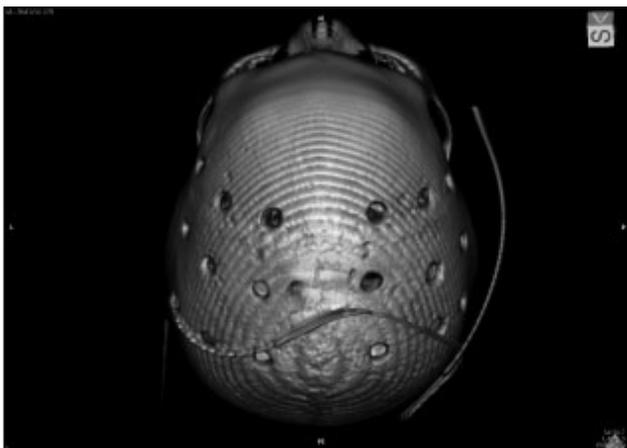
Postoperative 3-D CT reconstruction of patient's calvarium showing multiple burr-holes and subcutaneous drain.
